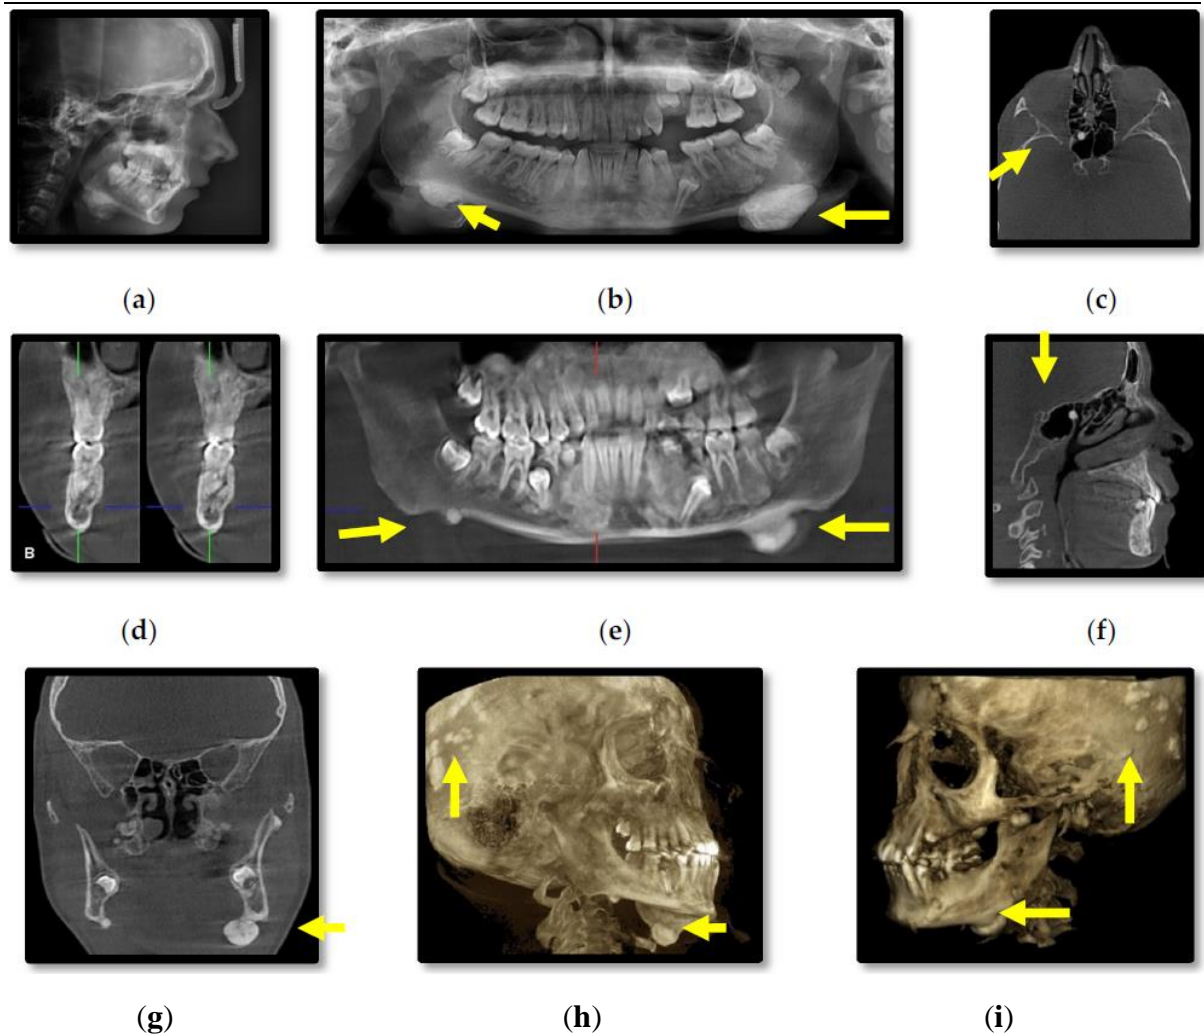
Patient III.2. Cephalometric (a) and panoramic (b) radiographs; CBCT axial (c), cross-section (d), panoramic (e), sagittal (f), coronal (g), 3D lateral-oblique (h) and 3D sagittal (i).
